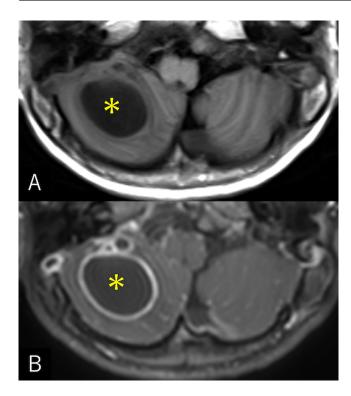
Pre- (A) and postcontrast (B) T1-weighted magnetic resonance images at the same level, performed at the second presentation, showing a cystic mass in the right cerebellar hemisphere (asterisk) with rim-like enhancement.
